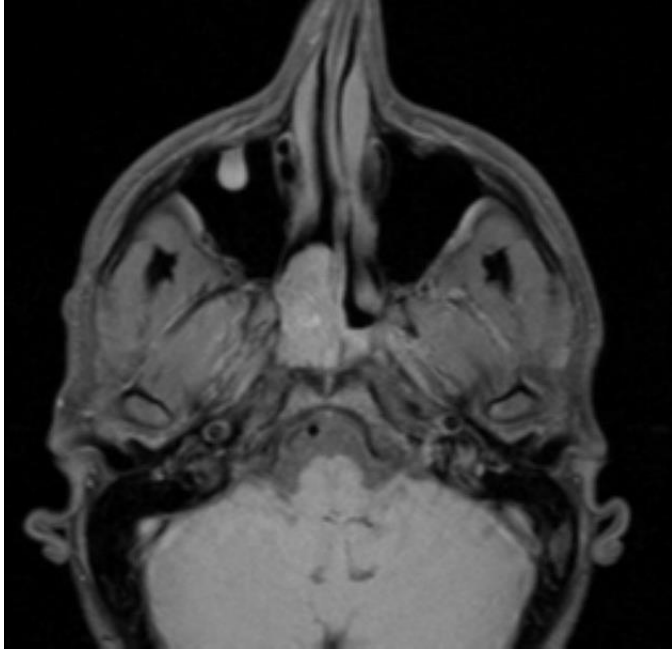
T1 weighted MRI showing intermediate density lesion
